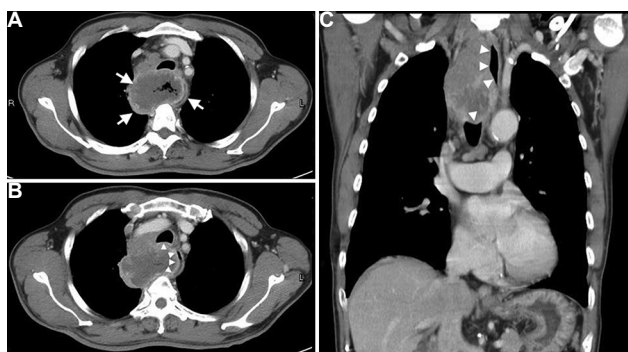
Contrast-enhanced computed tomography scans (A, arrows) in the transverse plane showing a large, lobulated soft-tissue mass (about 7 cm in diameter) arising from the oesophagus with central necrosis and trapped air bubbles in the mediastinum, which markedly compressed the trachea and invaded the posterior wall of the trachea (B: transverse plane and C: coronal plane; arrowheads).
